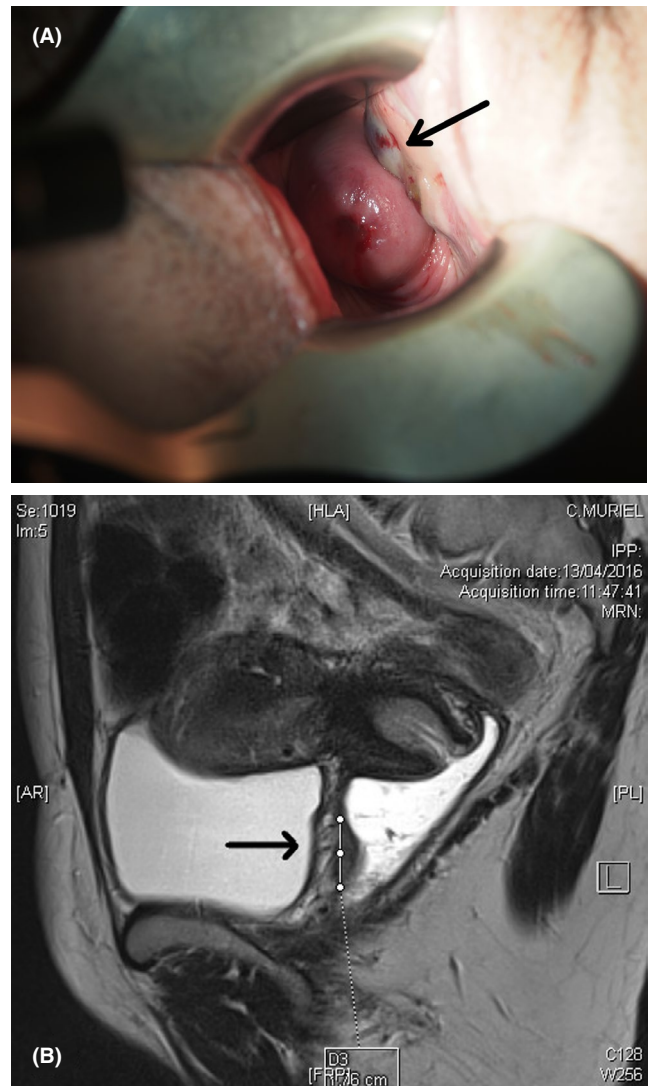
Vaginal examination (A) of the PMV lesion. Black arrow: PMV lesion. MRI-T2 sequence (B) of the PMV lesion. Black arrow: PMV lesion
